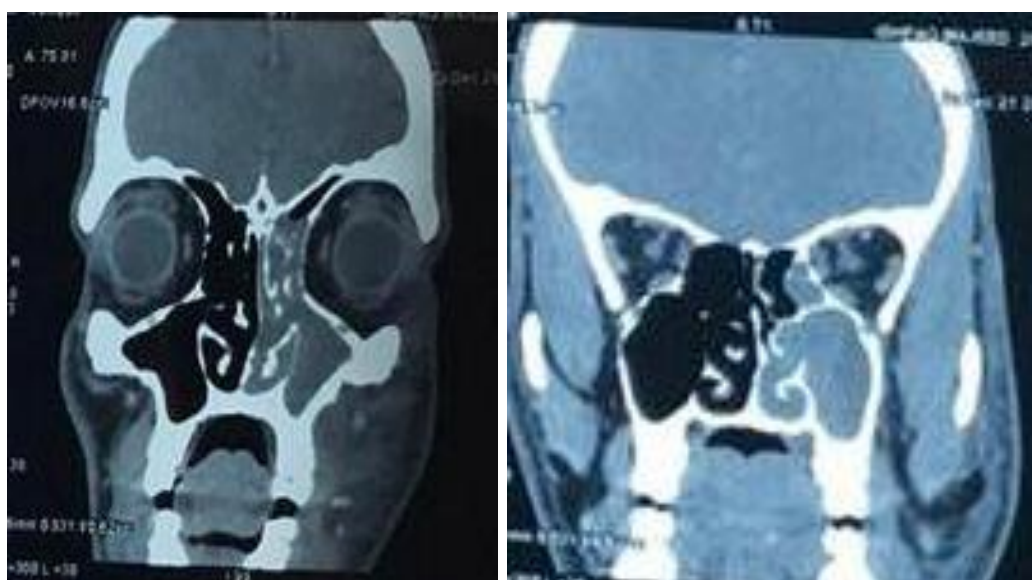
CT Scan Nose and PNS showing heterogeneously enhancing mass involving the left nasal cavity, left maxillary sinus with widened osteomeatal complex on the left side
